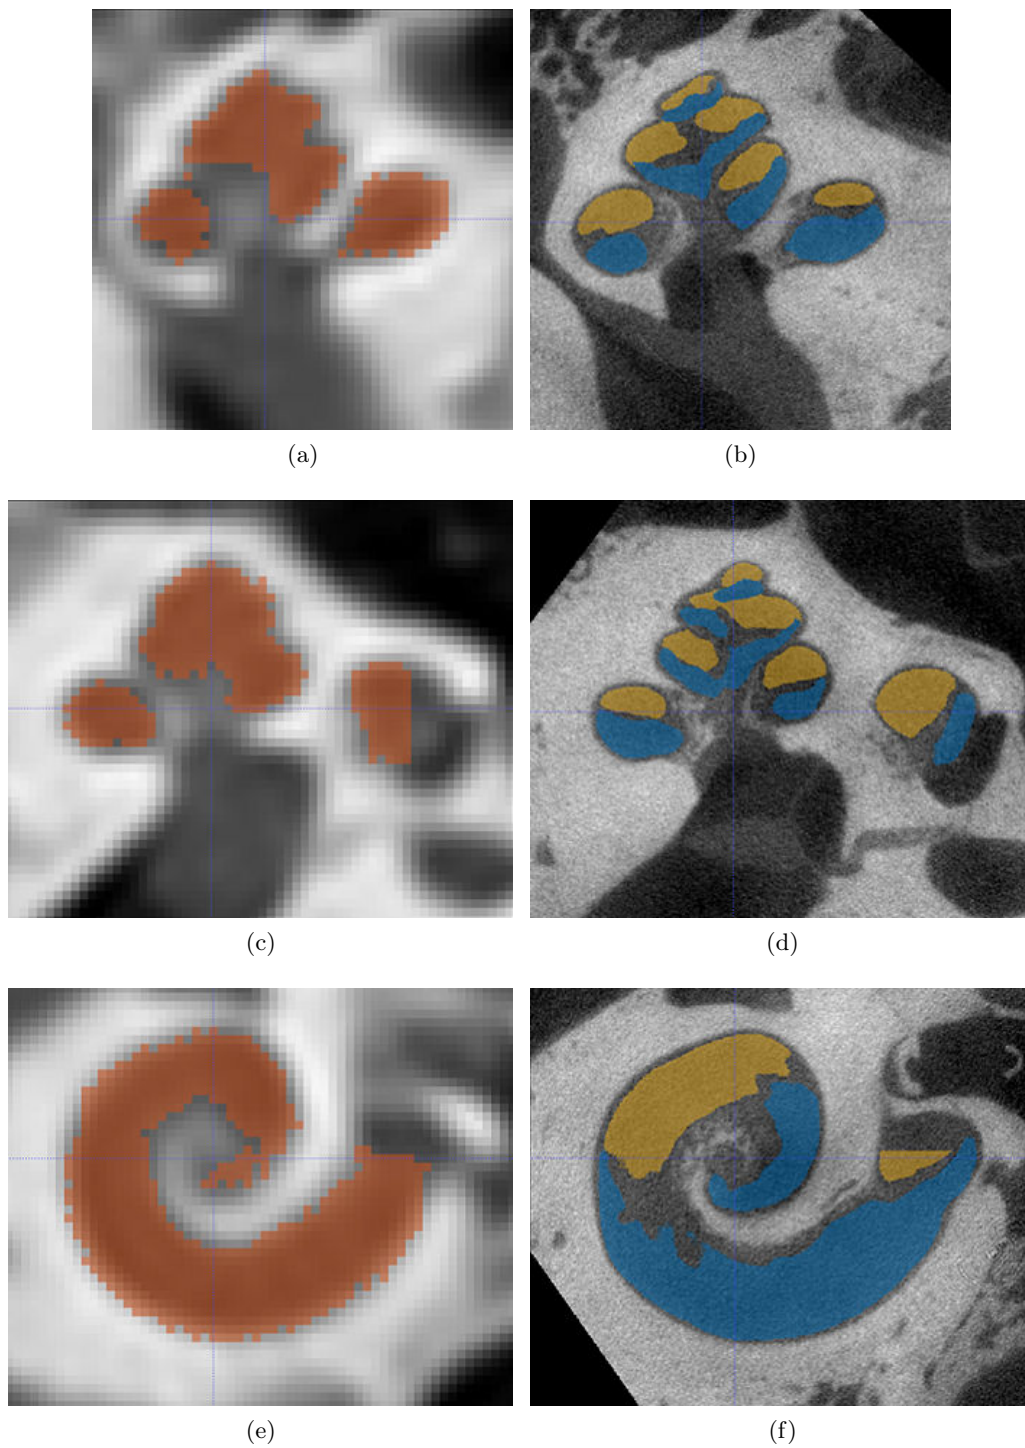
Slices of CT (a,c,e) and μ CT (b,d,f) with segmented cochlea (red), ST (blue) and SV (yellow).
